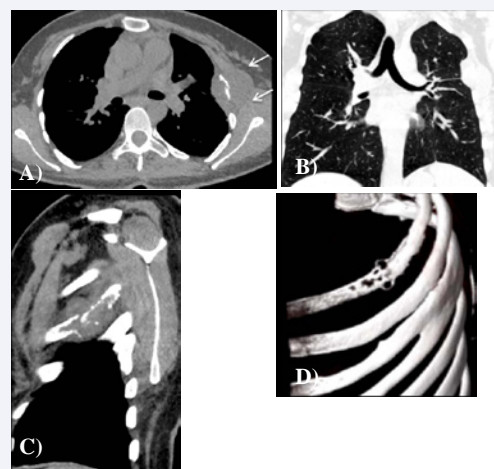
CT scan, axial image (a), three dimensional coronal(b)and sagittal(c) multiplanar reformations and Volume rendered coronal image (d), show chest wall mass causing destruction of the 3th left rib(arrows) without pulmonary cyst recurrence.
